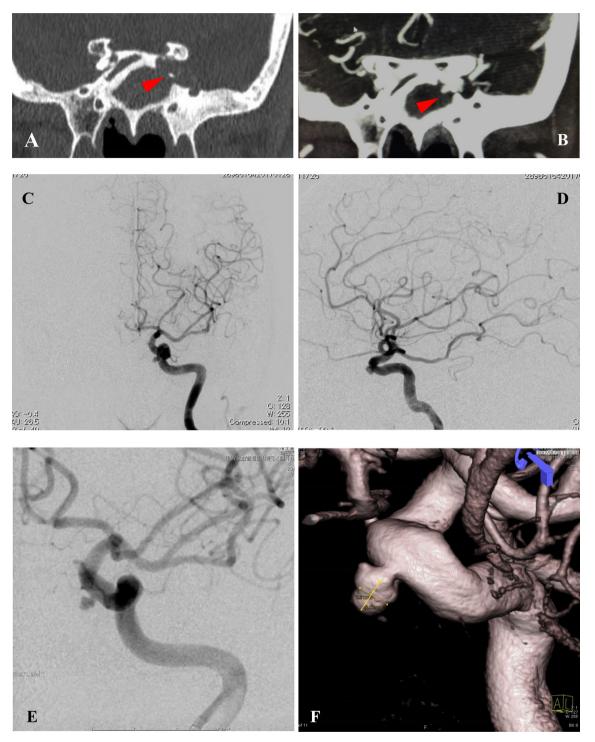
(A) Computed tomography (CT) scans showing a bone defect in the lateral wall of the left sphenoid sinus (arrowhead). (B) Coronal enhanced CT demonstrating the aneurysm protruding into the sphenoid sinus (arrowhead). (C and D) Anteroposterior and lateral digital subtraction angiography after left internal carotid injection revealing a true aneurysm. (E and F) Initial selective angiography of the left internal carotid artery.
